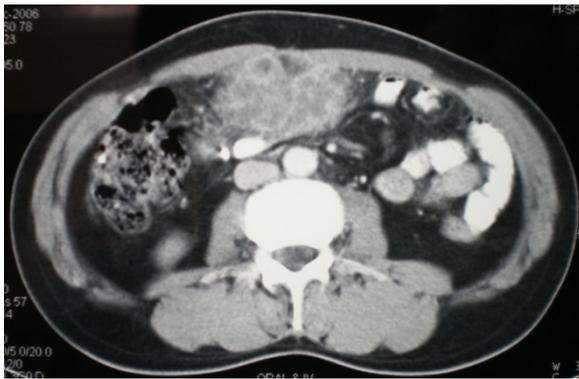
CT scan of abdomen shows heterogeneously enhancing space occupying lesion in supra-umbilical region in mesentery suggestive of mesenteric tumor
